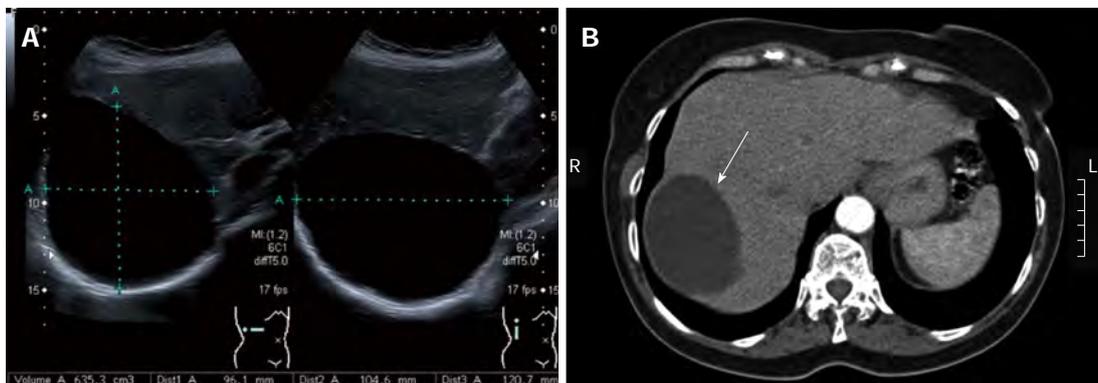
Simple cyst. A: On abdominal ultrasonography. Ultrasonography (USG) demonstrating a large simple cyst occupying the right hepatic lobe. Note the sharp and smooth border, oval shape, and anechoic echo pattern with the absence of septations and strong posterior wall echoes. The cyst size is indicated by the dotted lines; B: On abdominal computed tomography. Computed tomography demonstrating a sharply defined homogeneous hypodense cystic lesion (arrow) occupying the right hepatic lobe, which was diagnosed as a simple cyst.
